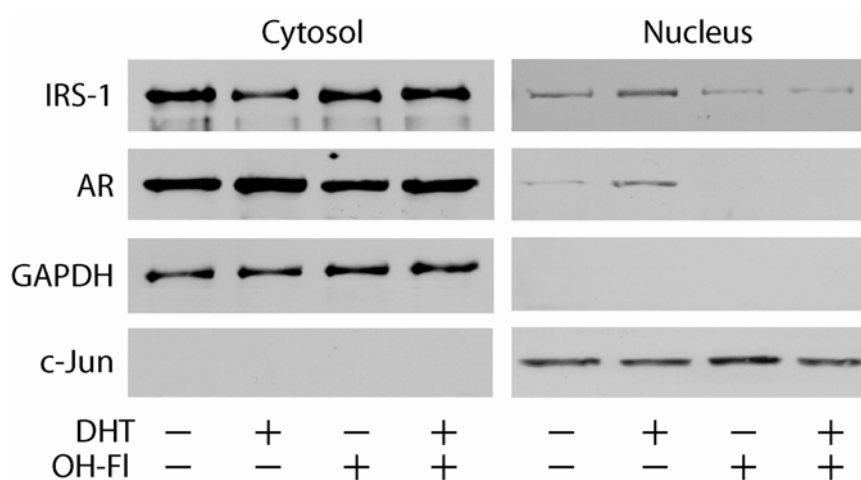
IRS-1 colocalizes with AR. MCF-7 cells synchronized in SFM were treated with 10^{-7} M DHT or 10^{-7} M OHFI in PRF-CT for 24 h. The expression of IRS-1 and AR was determined by Western blotting in 50 μ g of cytoplasmic or in 100 μ g of nuclear proteins using specific Abs, as described in Materials and Methods. The expression of GAPDH and c-jun was assessed as control of protein loading and purity of lysate fractions. The results were obtained after repetitive stripping and reprobing of the same filter. The results are representative of three independent experiments.
